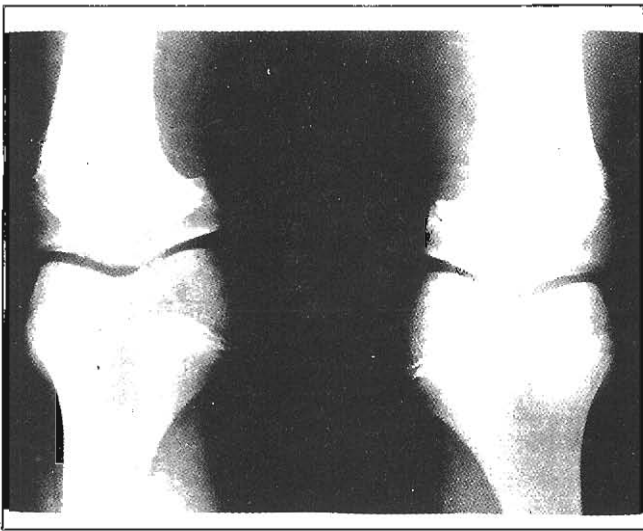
Radiographs of the knees of the proband at the age of 14.
